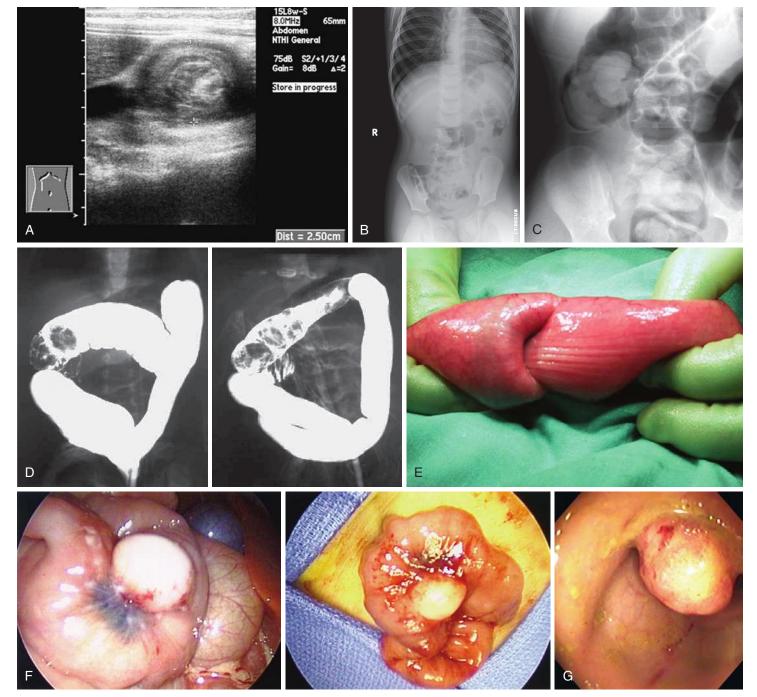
Intussusception. A, A "target lesion" can be seen on this ultrasound demonstrating intussusception. B, On occasion, an intussusception can be seen on a plain adopminal radiograph. Note the absence of air beyond the intussusception. C, Air enemas are used to both diagnose and reduce an intussusception. D, Barium outlines the intussuscepted segment before and after it is reduced. E, This is an example of an intussusception seen at laparotomy, necessary when reduction is not successful during a barium or air enema. F, A Meckel diverticulum can be a lead point for intussusception. G, An intestinal polyp can act as a lead point for intussusception. *(Courtesy Stefano Bartoletti, MD, and Mark Lowe, MD, Pittsburgh, Pa.)*
